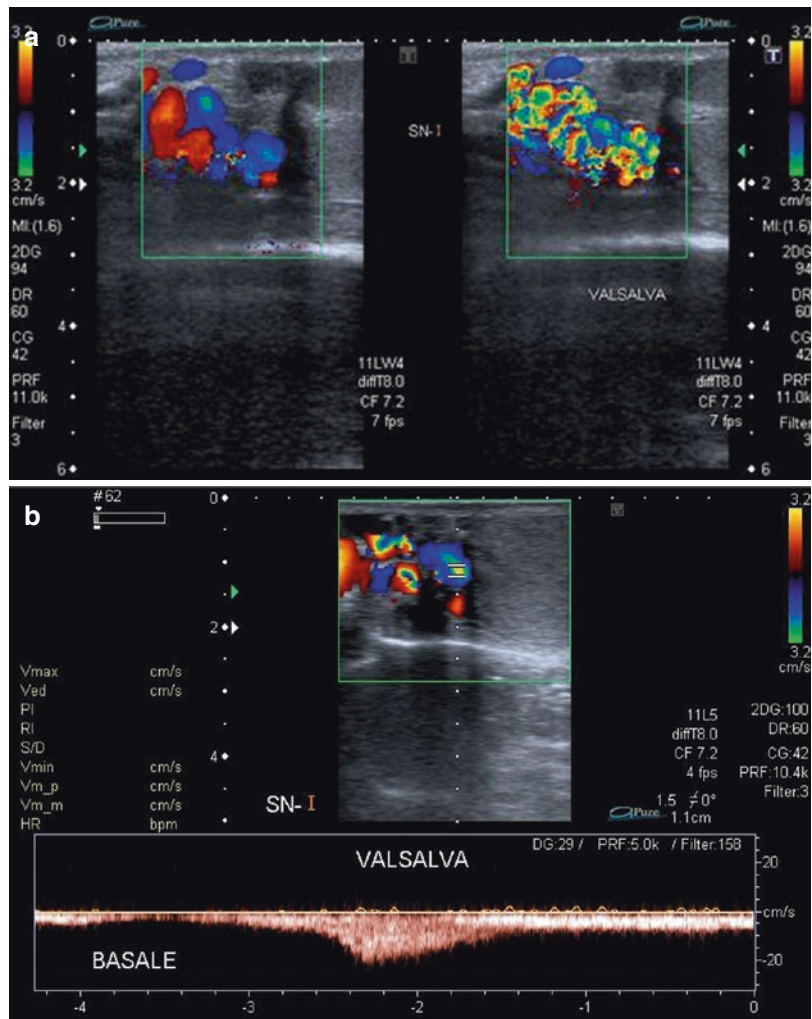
Sarteschi's grade 4 varicocele. Color Doppler images (a) and spectral Doppler analysis (b) obtained in supine position at rest and while standing during Valsalva maneuver. Dilated veins with reflux are visible also at rest. Reflux increases while standing during Valsalva
